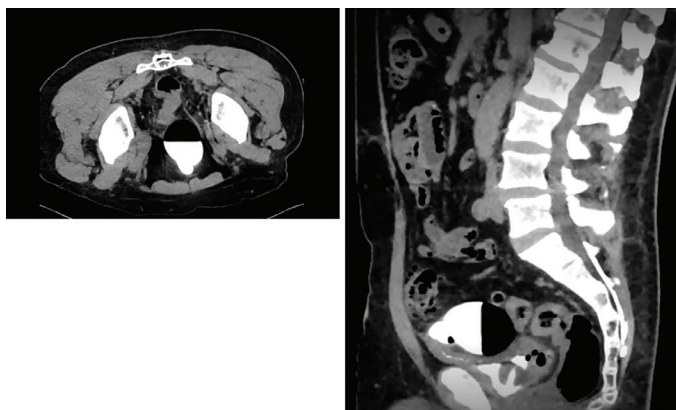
Axial and sagittal CT images showing the diverticulum's anterior and superior position along the bladder wall
